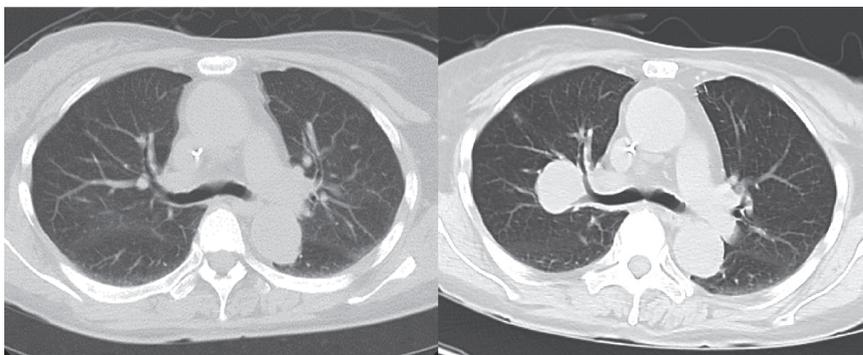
Chest CT scan images
